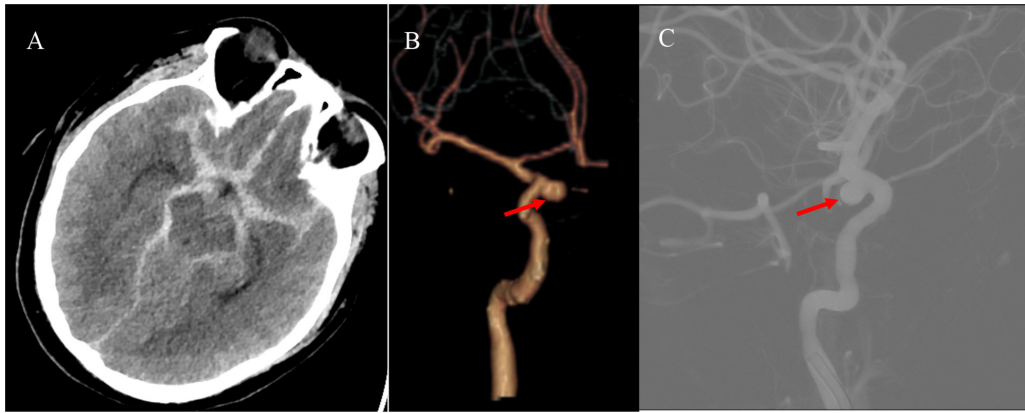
Preoperative imaging examination of the patient. (A) Initial brain CT showing diffuse subarachnoid hemorrhage. (B) Reconstructive CT angiogram and (C) digital subtraction angiography displaying the C5 segment of the right internal carotid artery aneurysm (red arrows). CT, computed tomography.
